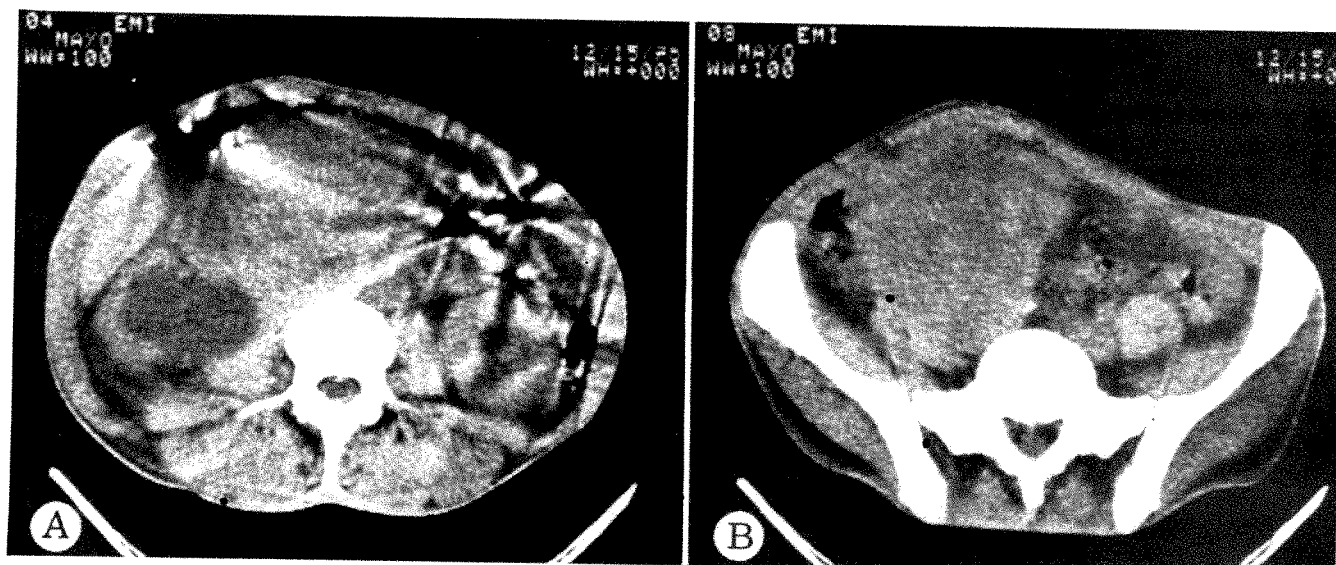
CT scans of 39-year-old man presenting with palpable mass in right lower abdomen after recent orchiectomy for seminoma. Right kidney non-functioning at the time of excretory urography. A, Hydronephrosis of right kidney associated with large mass occupying two-thirds of abdomen anterior to right kidney. B, Scan through pelvis showing portion of lower extent of gigantic abdominal mass obstructing right ureter and bulging anterior abdominal wall. Metastatic seminoma confirmed by biopsy.
